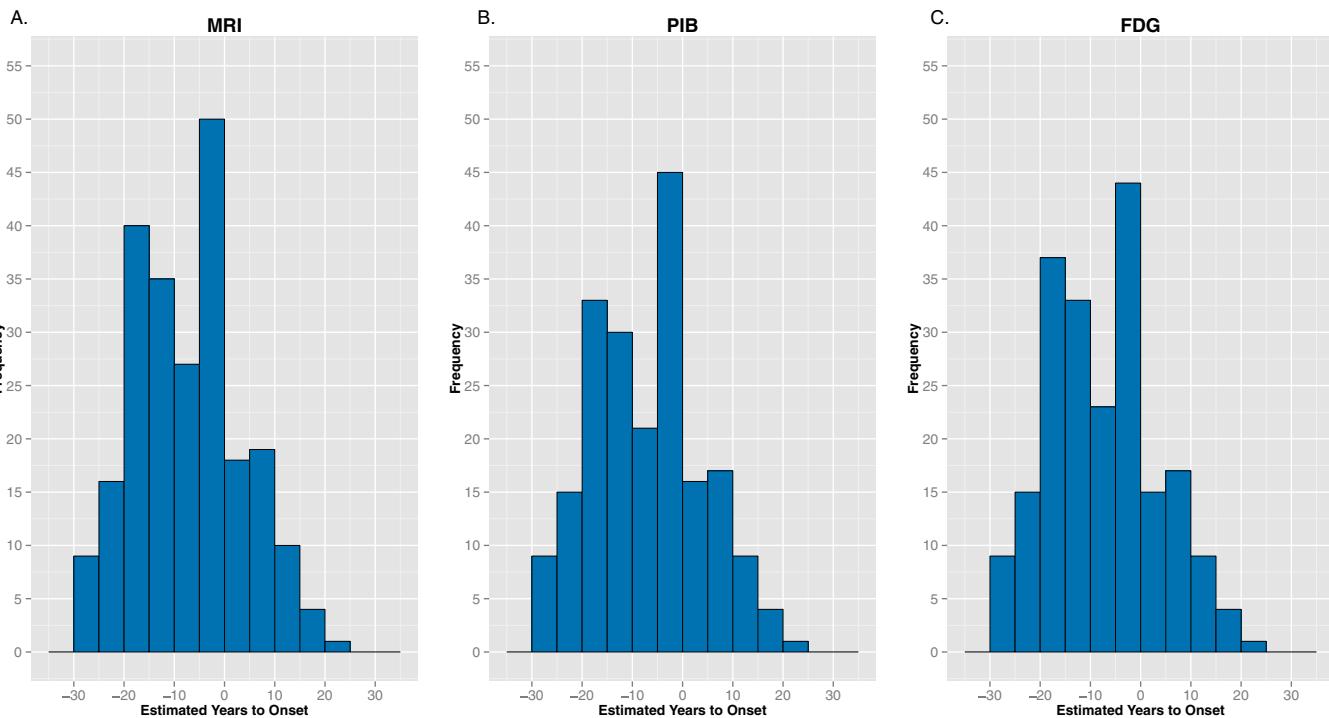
Number of participants with MRI (A), PiB (B), and FDG (C) scans within 5-y EYO intervals from -30 to 30. Mutation status is not indicated to reduce the likelihood of participants' guessing their genetic status.
